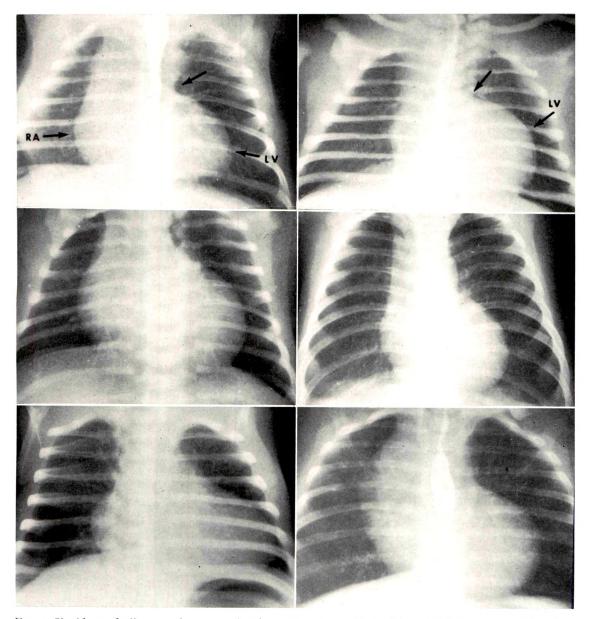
Significant findings on the conventional roentgenogram. Upper left and right: Posteroanterior views demonstrate the concavity of the left heart border in the region of the pulmonary artery segment (unlabelled arrow) and the convexity of the lower portion of the left heart border due to the enlarged left ventricle (LV). The enlarged right atrium produces a mild convexity of the right heart border inferiorly (RA). Note the generalized diminution in size of the pulmonary vasculature. Center left and right: Roentgenograms demonstrate the range in heart size exhibited by patients with a tiny right ventricle. Lower left and right: The roentgenogram on the left shows gross cardiomegaly. At autopsy, the patient was found to have a large right ventricular cavity with an incompetent tricuspid valve. Roentgenogram on the right shows mild cardiomegaly in a patient found at operation to have a normal sized right ventricle.
